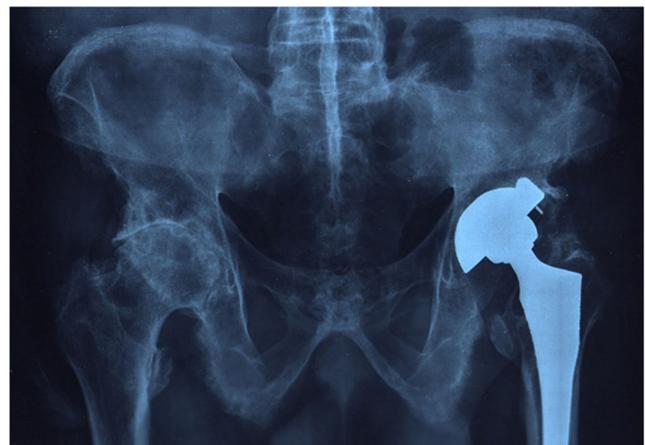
X-ray image of left hip of 54-year-old male with axial spondyloarthritis. Typical radiographic features of hip involvement in a patient with axial SpA: global space narrowing, collar osteophytes around the femoral neck, erosions, and subchondral cysts
